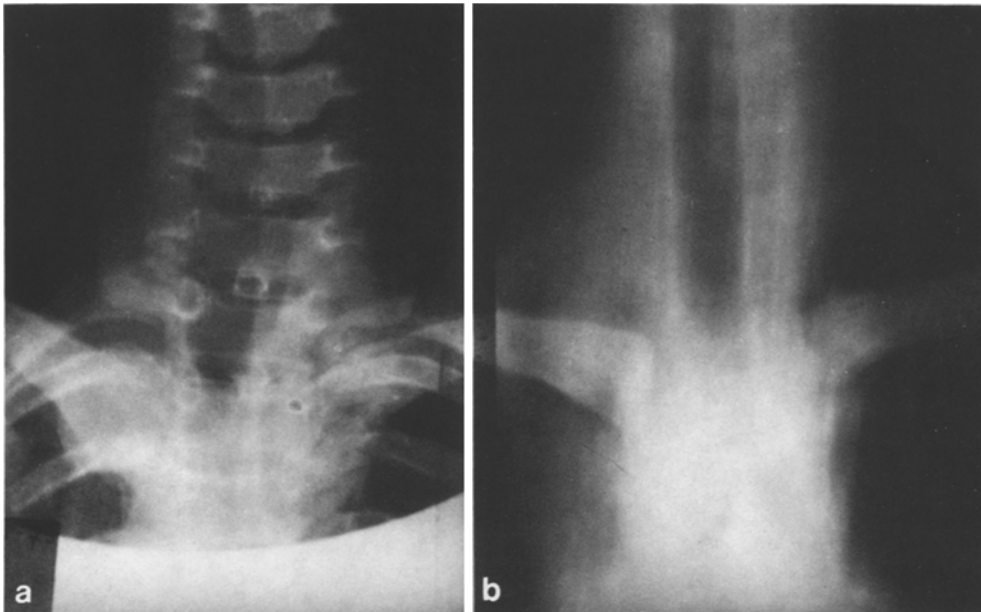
a, b. Tuberculosis of the left sternoclavicular joint (stage 4). a Radiograph; b Tomograph
